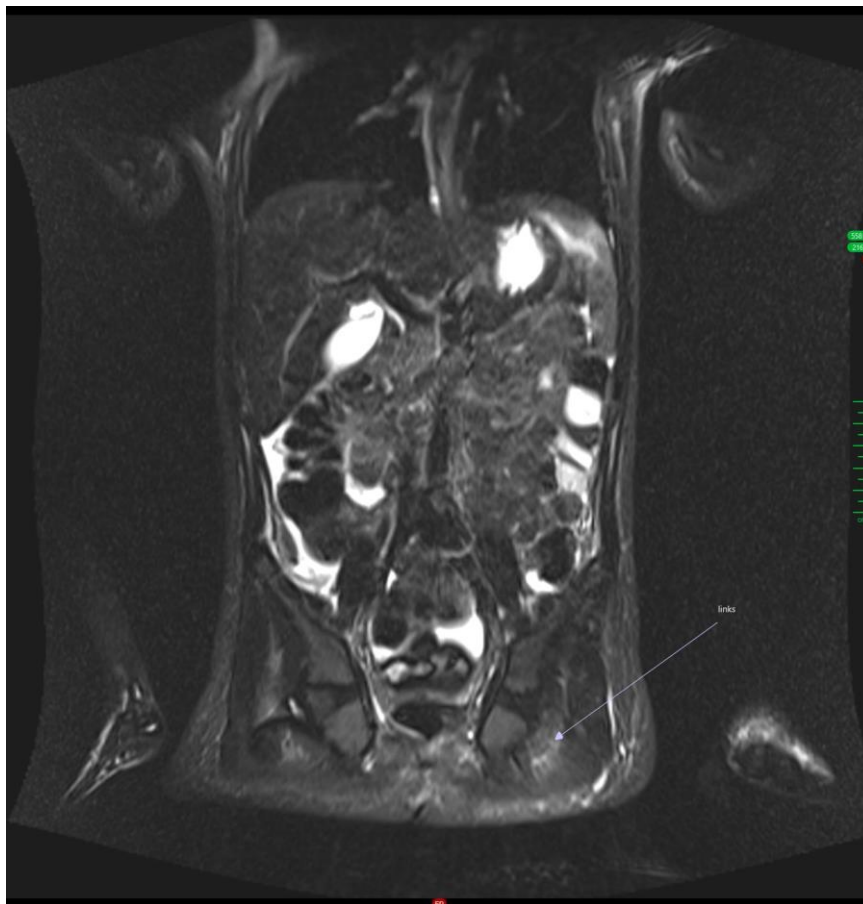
MRI finding: Pelvic muscles increased signal intensity indicating myositis
